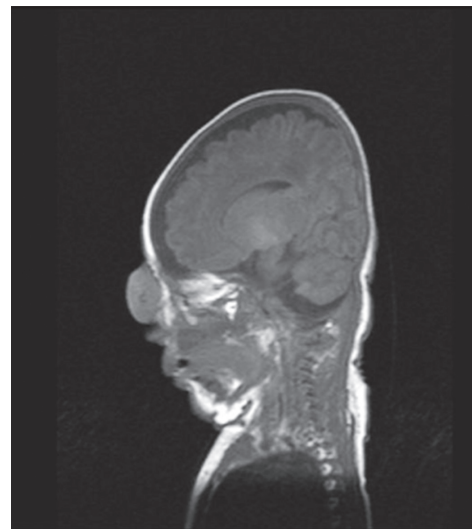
Heterogeneous, hypointense lesion on T1 and T2-weighted magnetic resonance imaging image
